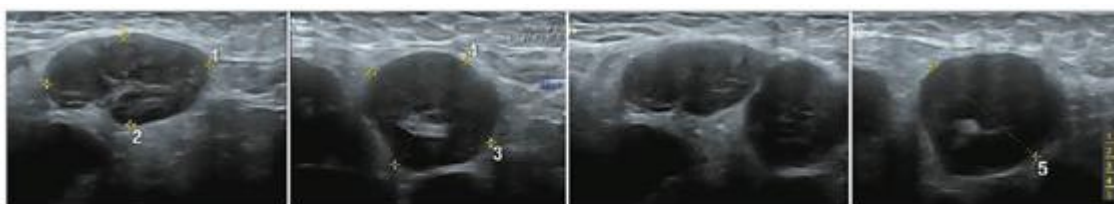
Ultrasound data of axial lymph nodes in a pregnant woman with HL.
